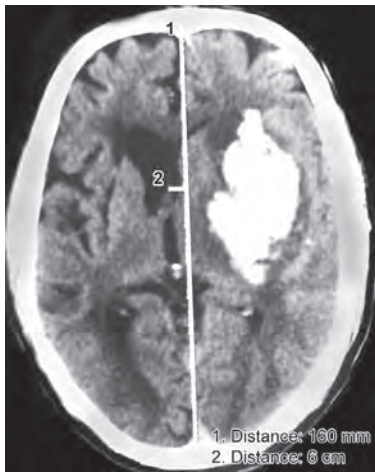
Ganglio-capsular haemorrhage-CT
